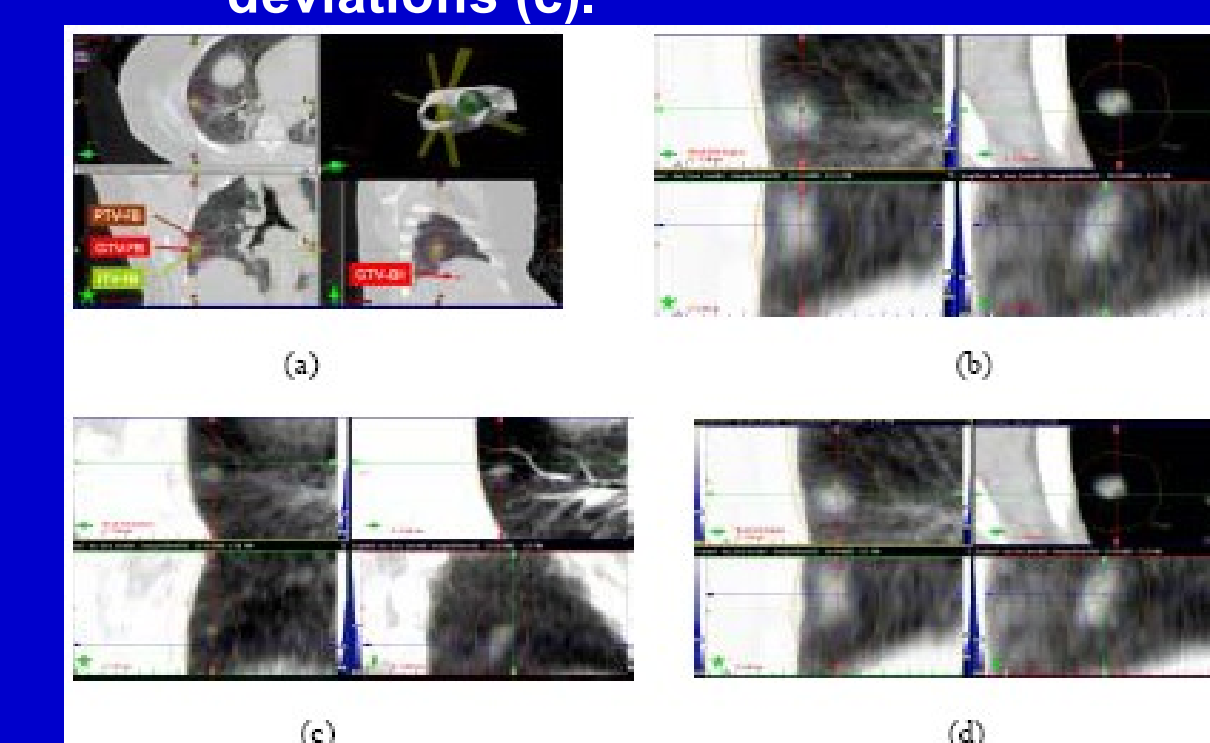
Lung case – treatment plan (a), CBCT pre-shift (b), CBCT after shift before treatment (c), and CBCT after treatment (d).
